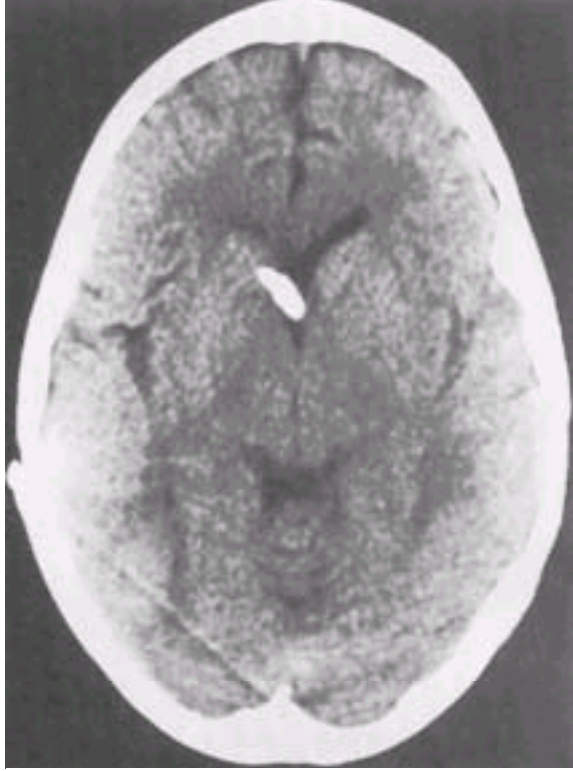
Cranial computed tomography scan of the patient with shunt disconnection shown in [Figure 61-17](#) . This CT scan at presentation reveals ventriculomegaly. After revision, the ventricles returned to normal size (see [Fig. 61-20](#) ).
